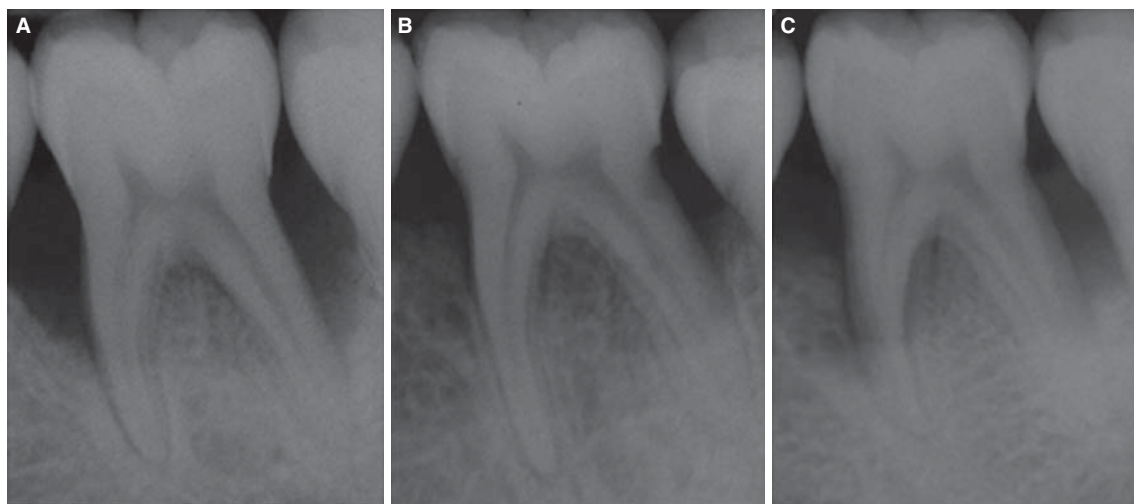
Radiographic appearances of an intraosseous defect treated with BG/BM. (A) Baseline; (B) Post-operative 6-months; (C) Post-operative 5-years.
